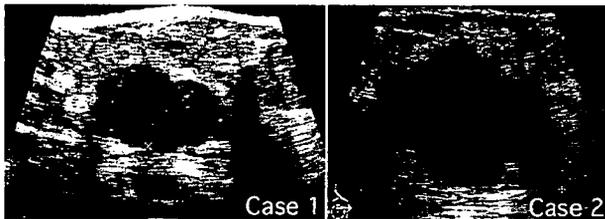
Ultrasonography showed lobulated, hypoechoic tumors with well-defined borders in both cases.
